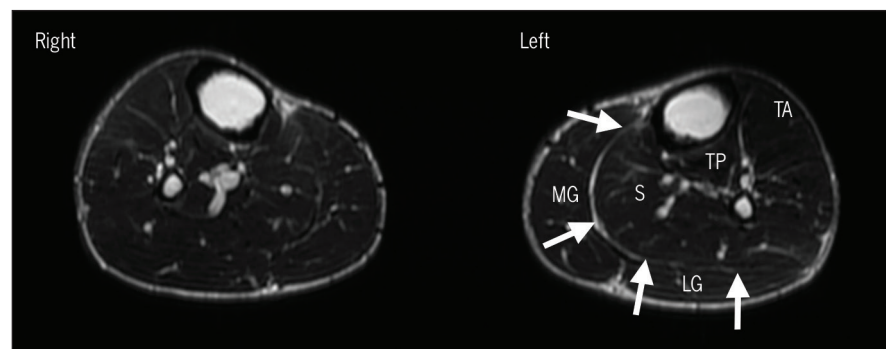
Exit physical (17 days post injury): T2-weighted axial magnetic resonance imaging (fast recovery, fast spin-echo) image. The white arrows represent minimal edema. Abbreviations: LG, lateral gastrocnemius; MG, medial gastrocnemius; S, soleus; TA, tibialis anterior; TP, tibialis posterior.
